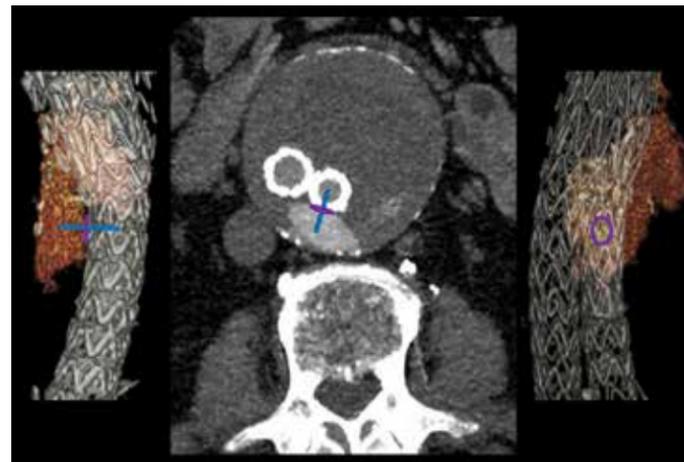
Endoleak Nidus/Planning lines from CTA with 3D model
